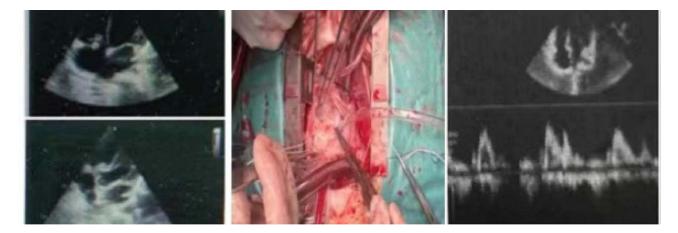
Preoperative cardiac ultrasound, intraoperative vegetation, and postoperative cardiac ultrasound of the child.
